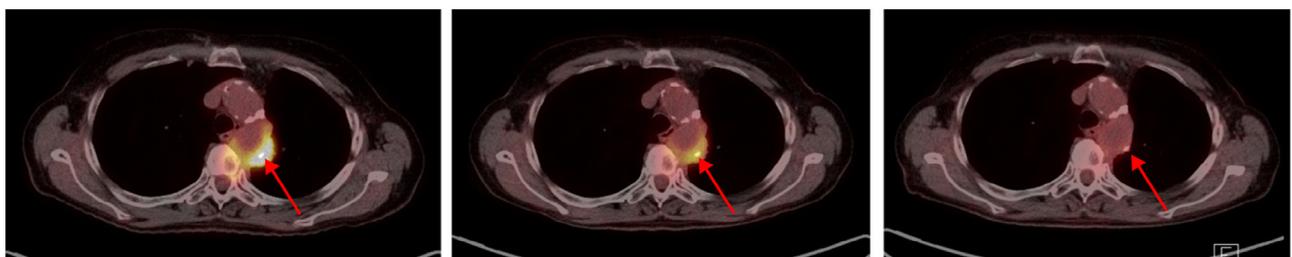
The 2-deoxy-2-fluoro-D-glucose positron emission tomography images of a patient showing the primary tumor (red arrow) before radiation therapy (maximum standardized uptake values [SUV_{max}]: 16 [left]), midtherapy (SUV_{max} : 6.5 [middle]), and 6 weeks after the end of therapy (SUV_{max} : 3.3 [right]). This patient was treated with radiation therapy without the addition of erlotinib.
